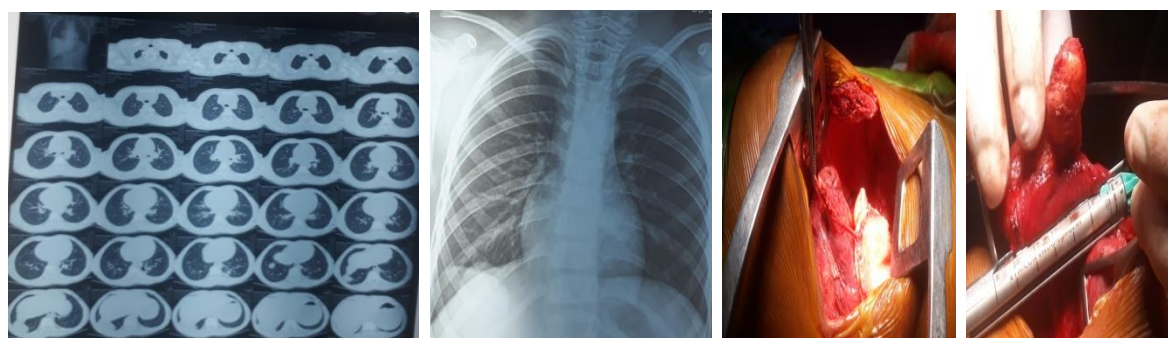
Chest Xray and CEMRI and intraoperative picture of cardiac hydatid cyst
